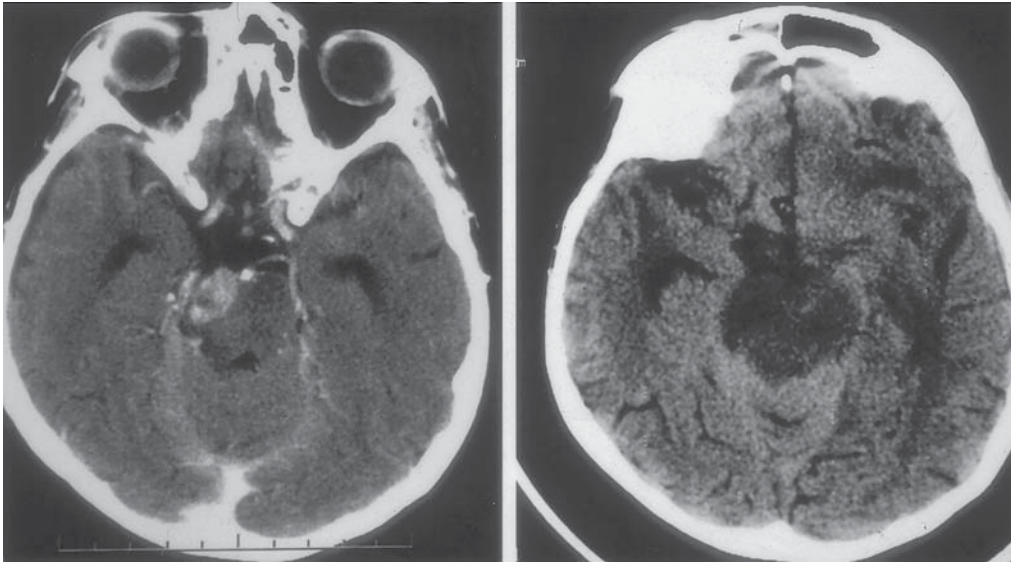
Acute obstructive hydrocephalus from an extra-parenchymal metastasis from rhabdomyosarcoma (left). A follow-up CT scan shows brainstem ischemia and generalized atrophy (right).
